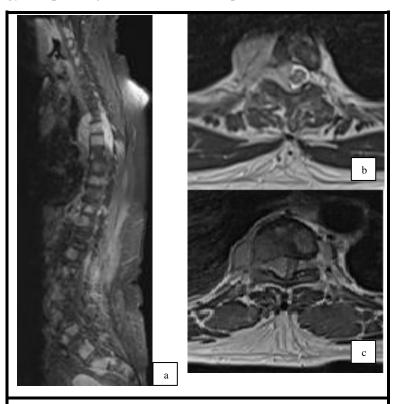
Pre-operative MRI images. a Sagittal view whole spine T2W. b Axial view T2W T5. c Axial view T2W at T10 level.
